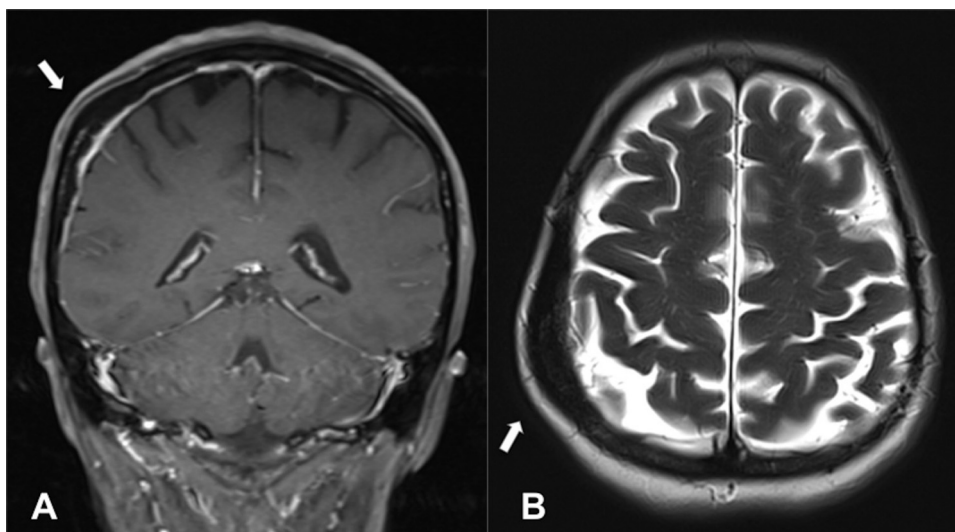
(A) T1-weighted coronal gadolinium-enhanced MRI scan showing an expansive diploic lesion (white arrow) without enhancement or dural invasion. (B) T2-weighted axial scan showing the expansive non-lytic tumor.
